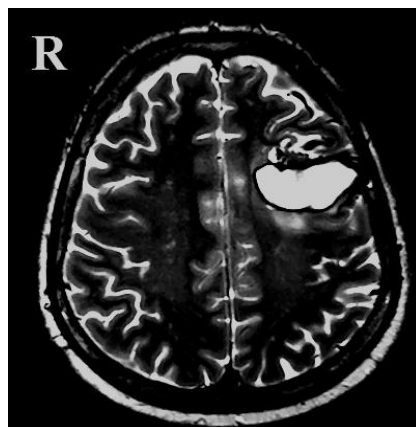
Brain Magnetic Resonance Imaging (pre embolization)
